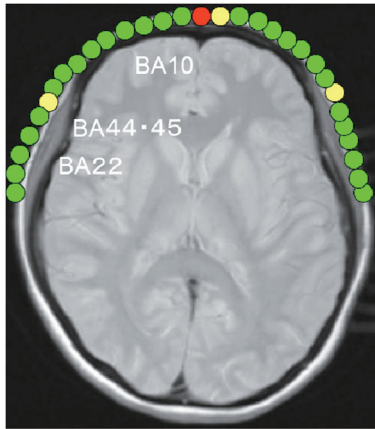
Measurement positions shown in an MRI image of the brain.
